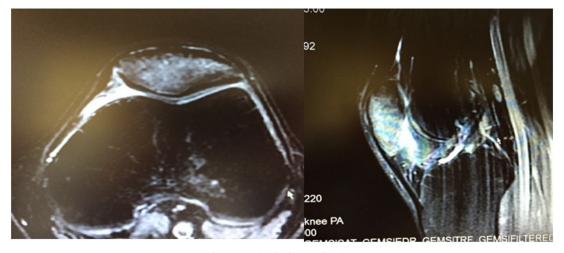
MRI in the first application.
